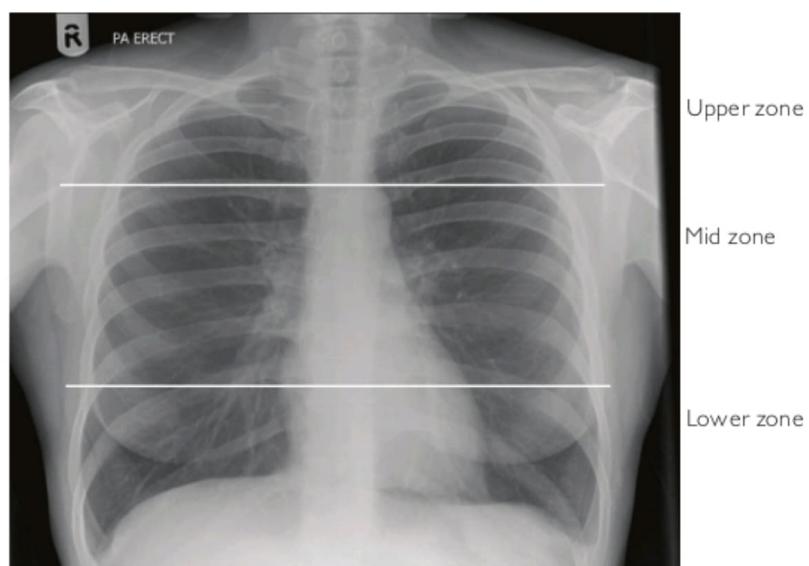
Zones on the chest x-ray
